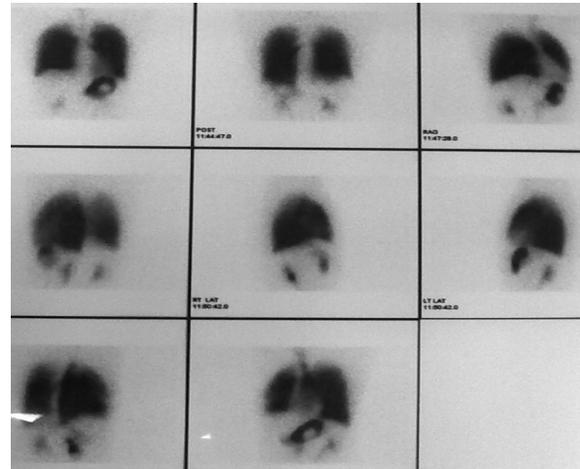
Perfusion ventilation scintigraphy showing insignificant sub-segmental perfusion defects in lateral basal, anterior and posterior basal segments of right lung and normal tracer distribution in the left lung
